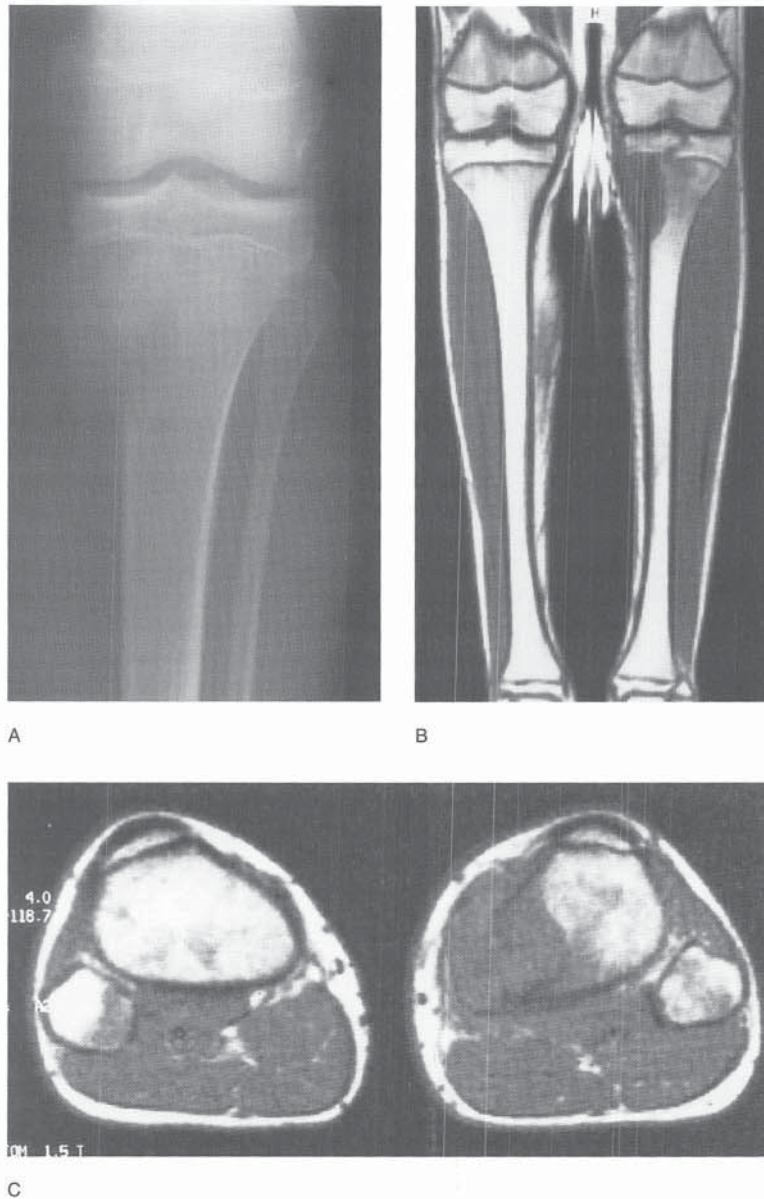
High-grade osteosarcoma in a 16-year-old boy. A, AP radiograph of the tibia. There is a destructive lesion of the proximal metaphysis with internal mineralization. It is poorly margined and has destroyed the cortex. It appears to stop at the growth plate. At this age, an osteosarcoma would be the most likely diagnosis. B, T1-weighted MR image showing the medullary extent of this tumor and the soft tissue mass. The epiphysis appears to be uninvolved except for a linear signal abnormality that may represent a fracture. The adjacent joint appears to be uninvolved. C, Axial MR image showing the extent of the soft tissue mass and the relationship of the lesion to the popliteal vessels. The vessels are uninvolved. An incisional biopsy showed that the tumor was a high-grade osteosarcoma.
